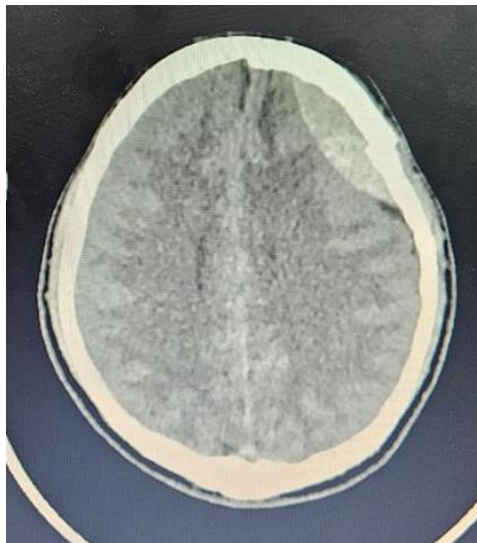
Cranial CT, Epidural Frontal Hematoma with fracture
